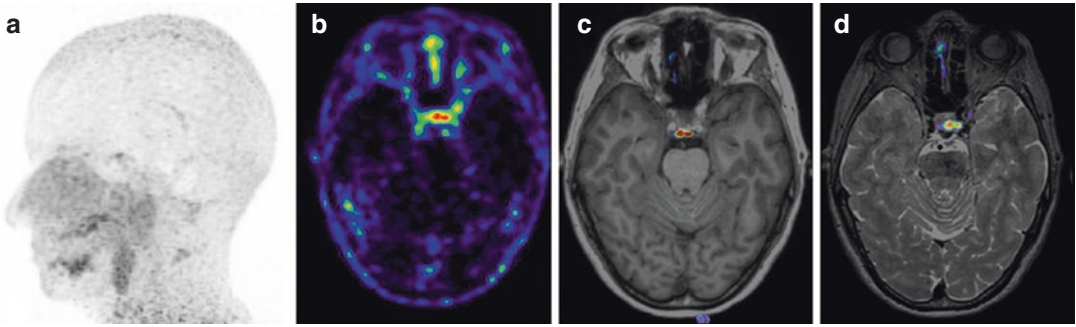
PET 3D maximum intensity projection of the physiological bio-distribution of ⁶⁴Cu-DOTANOC in the brain (a). Axial PET view (b) shows focal uptake in the pineal gland, without corresponding abnormalities in T1 (c) and T2 (d) weighted PET/MRI views, performed on a hybrid PET/MRI scanner
